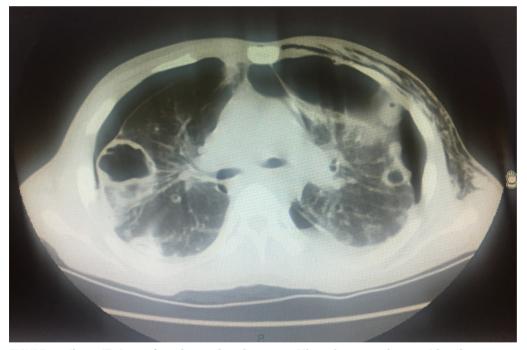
Chest CT Scan after chest tube placement. Bilateral pneumothorax with subcutaneous emphysema and multiple cavitations. Right and left chest tubes in place.
